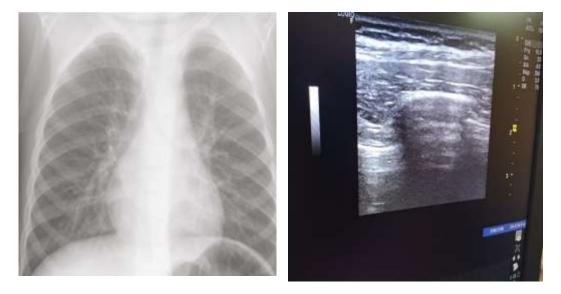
(A case of abnormal CXR and normal LUS) A 7-year-old male, presented with clinical diagnosis of pneumonia. A) CXR demonstrated pulmonary infiltrates B) normal lung ultrasound.
